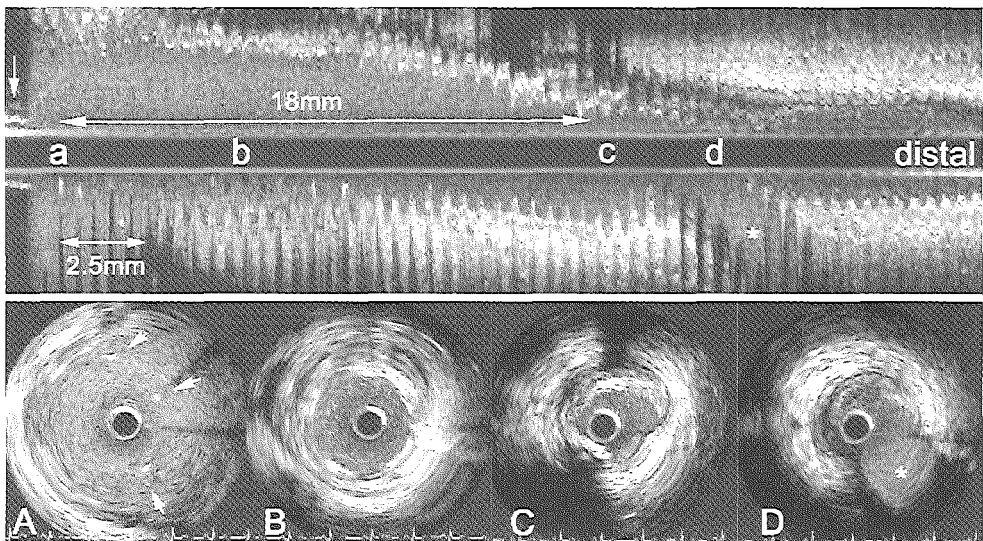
Intra coronary ultrasound (ICUS). Longitudinal reconstruction (top panel) of an ICUS pullback (speed was 0.5 mm/s) through the left main stem. Panels A,B,C and D show the ICUS cross sections, indicated in the longitudinal reconstruction by the corresponding characters a through d. The circumflex artery is indicated by * (in panel D and the longitudinal reconstruction). Panel C is located just distal from the stent and shows an eccentric mixed plaque with 30° superficial calcium at 7 o'clock and a spot of calcium at 12 o'clock. No hyperplasia was noted within the stent (B). Panel A is located outside the coronary artery showing stent struts (arrows) in the aorta. The longitudinal reconstruction shows the stent protruding 2.5mm (short double headed arrow) into the aorta. The arrow at the far left side of the longitudinal reconstruction indicates the 6F guiding catheter.
